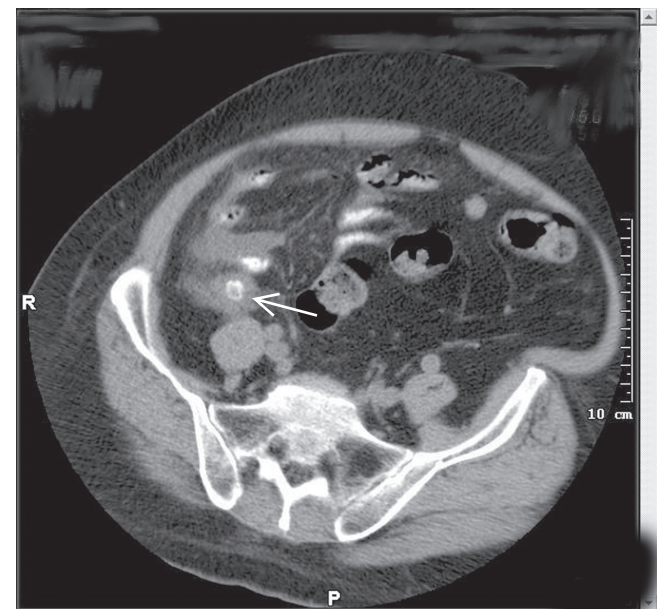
A pelvic computed tomographic scan of a patient with a distant history of right lower quadrant abdominal pain with recurrent acute attack demonstrating an inflamed and thickened appendix with surrounding fat stranding (white arrow). A gangrenous appendix was removed laparoscopically.
